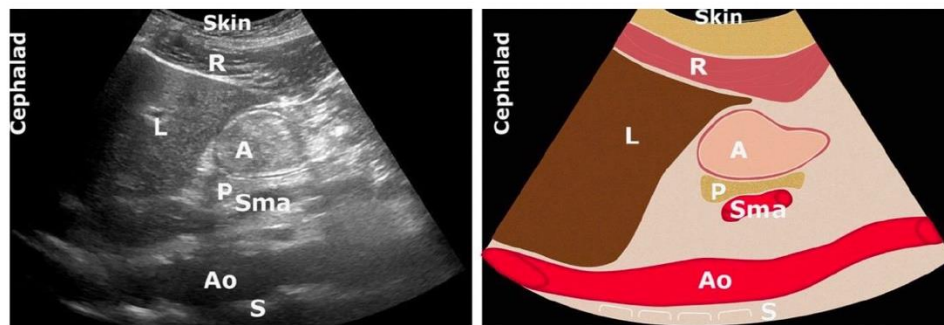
Ultrasound image showing late stage solid gastric contents. R – Rectus abdominis muscle, A – antrum, Ao- Aorta, L – Liver, P – pancreas, Sma – superior mesenteric artery, L – liver, S - spine
